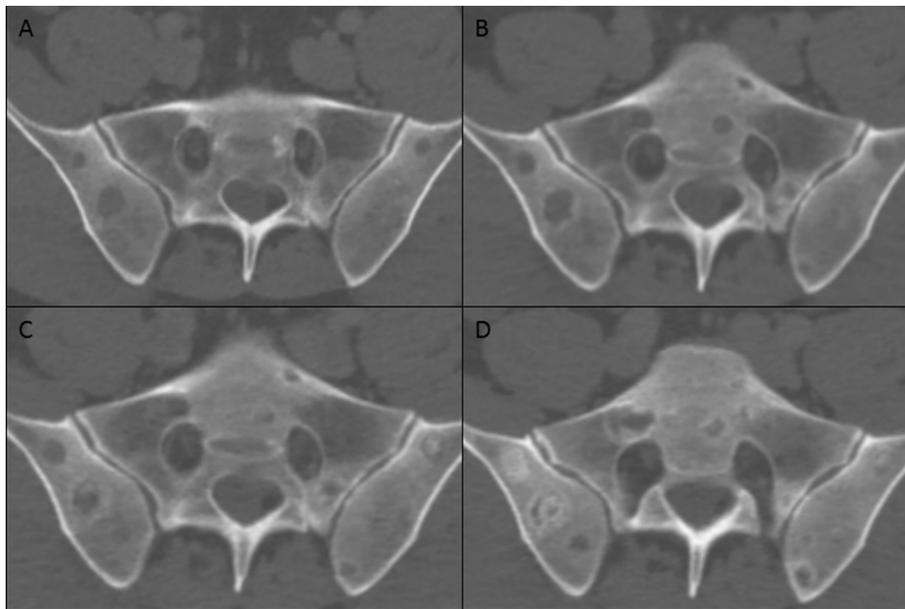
Serial CT assessment of lytic skeletal metastases. Initial assessment (A) demonstrates multiple lytic skeletal metastases demonstrated in the iliac bones. Six months later, after four courses of carboplatin and paclitaxel, the interval CT assessment (B) demonstrates progressive disease with increase in size of lytic skeletal metastases and a new lesion in the sacrum in this image. First postassessment CT (C), after 2 months of abiraterone therapy, demonstrates stable size of bony metastases with internal and marginal sclerosis seen reflecting the early features of bone healing. An assessment study at 1 year (D) demonstrates further increased sclerosis of bone lesions, reflecting bone healing and sclerosis of prior subtle/occult metastases. CT, computed tomography.
